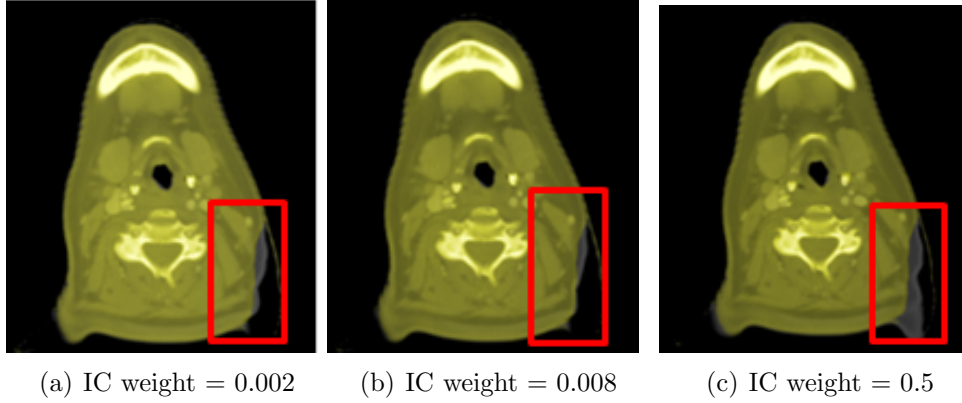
Transverse plane images of Patient X showing an overlap between CBCT (yellow) and deformed pCT (grey). Registration was performed using different values of IC weight: (a) 0.002, (b) 0.008 and (c) 0.5. Soft tissues are better aligned using smaller weights of IC penalty term (red square).
